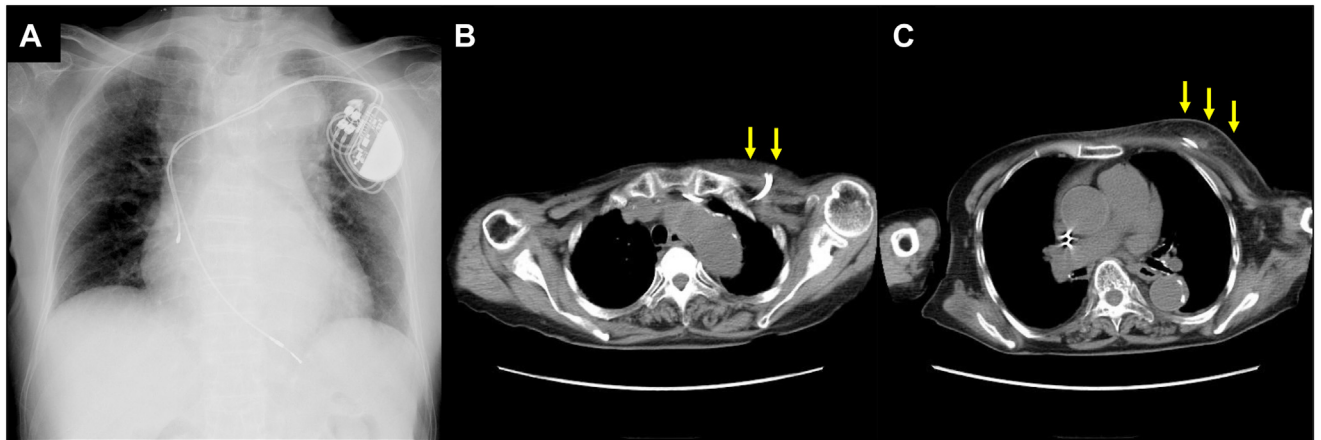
Chest radiography and computed tomography on admission. A: Chest radiography. B, C: Inflammation was suspected (yellow arrow).
